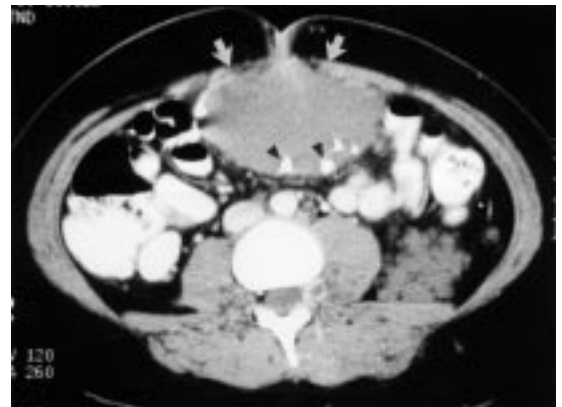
Axial computed tomography (CT) shows an intra-abdominal venous malformation that appears as an ovoid mass (arrows) anterior to the small bowel loops, with several phleboliths (calculi) (arrowheads). CT is not able to differentiate between the types of venous malformations. In this example, the multiple phleboliths are a defining feature; otherwise, the CT is not diagnostic.
